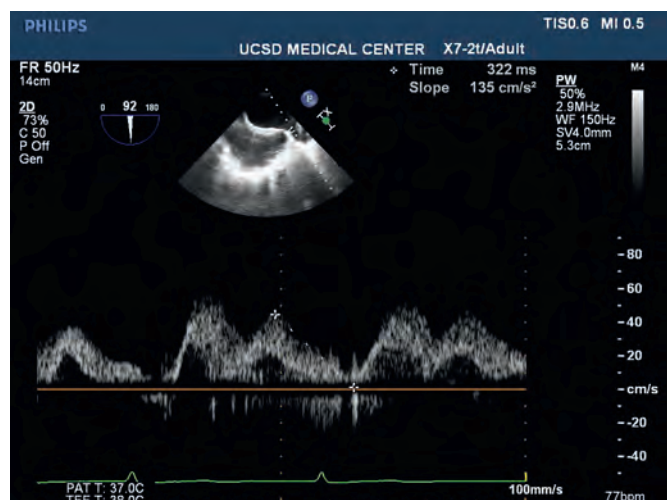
Pulsed-wave Doppler echocardiographic S and D waves from the right upper pulmonary vein in a patient with normal left atrial pressures. Deceleration time of the D wave is 322 milliseconds in this example. FR, Frequency; PW, pulsed-wave. (Courtesy University of California San Diego, La Jolla, Calif.)
